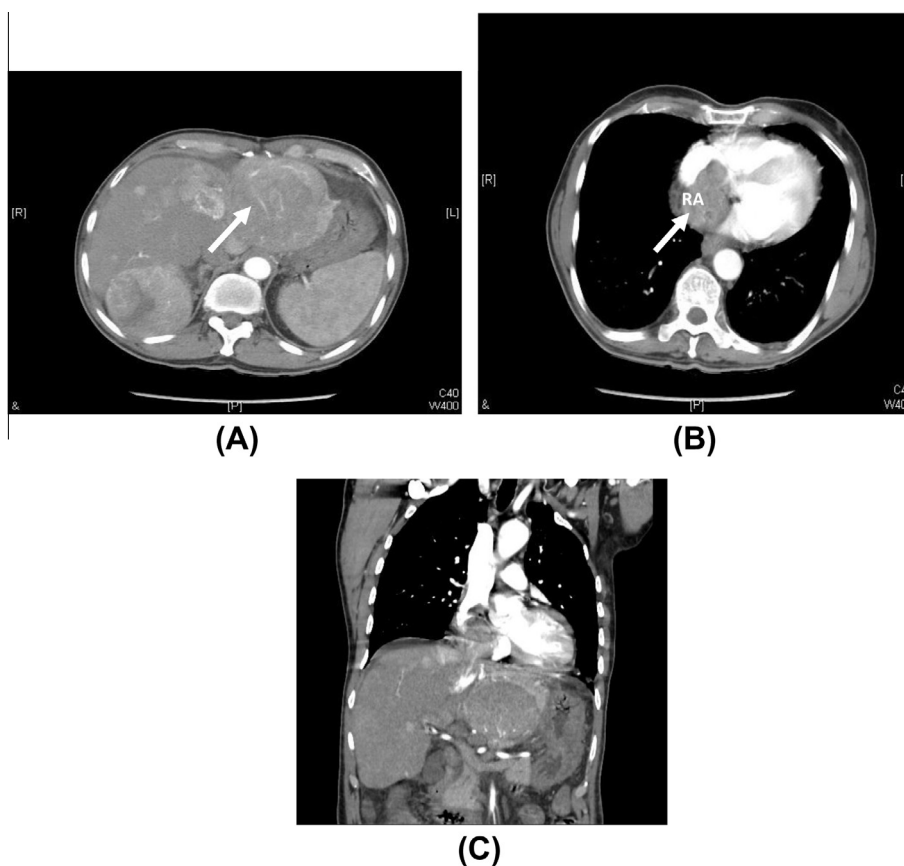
(A) CT scan of abdomen shows the hepatic mass. (B) CT scan of chest shows the Right atrial mass. (C) Coronal CT showing the extension of the tumor to RA (see arrows).
